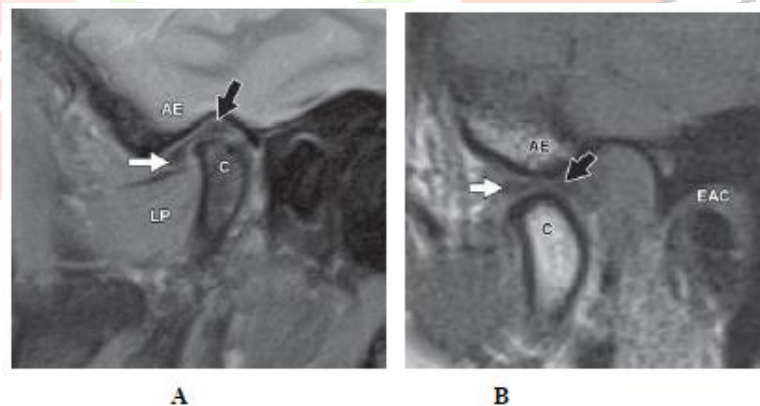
35-year-old woman. Closed-mouth proton density-weighted fat-saturated image (A) and open-mouth T1-weighted sagittal image (B) show hypoechoic biconcave shaped disk with anterior (white arrow) and posterior (black arrow) bands. Posterior band of disk is at 11–12 o'clock position in closed-mouth view. Lateral pterygoid muscle (LP) is anterior to condyle (C). AE = articular eminence, EAC = external auditory canal.^[19]
